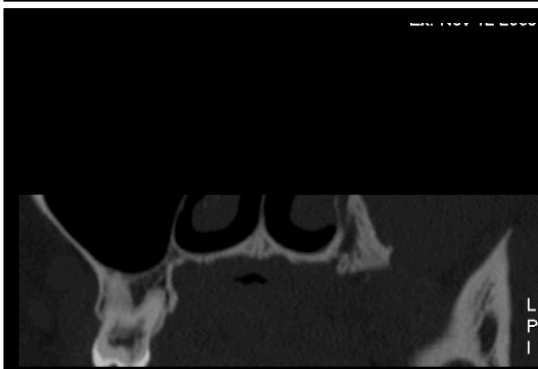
Coronal plane. CT Maxilla
